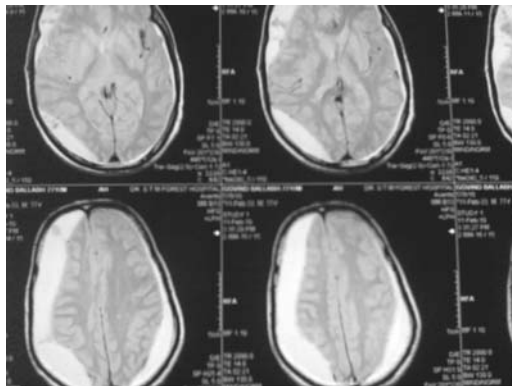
MRI Head (T2WI) showing bilateral CSDH
